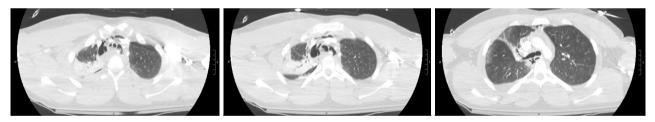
(CC8805 CT CAP from 02/03/2020). Gas seen around the trachea and right mainstem bronchus, suggestive of a tracheal injury. Extensive pneumomediastinum extending into the superior neck. CT, computed tomography; CAP, chest, abdomen and pelvis.
